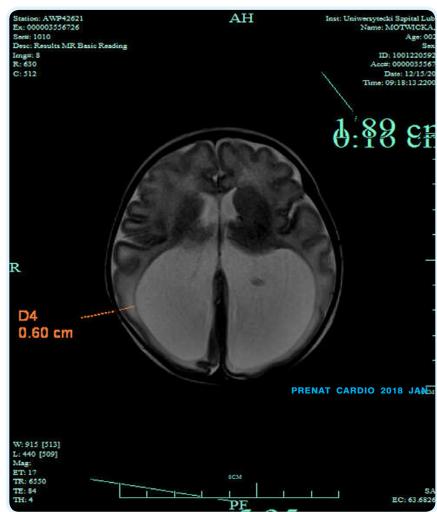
MRI transverse view ventriculomegaly of occipital horns
